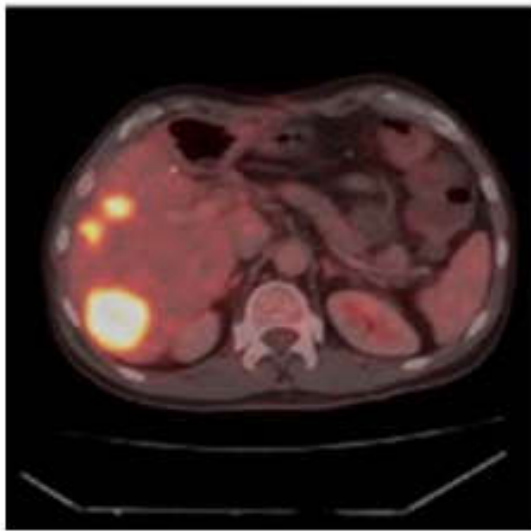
Original CT scan image of liver
